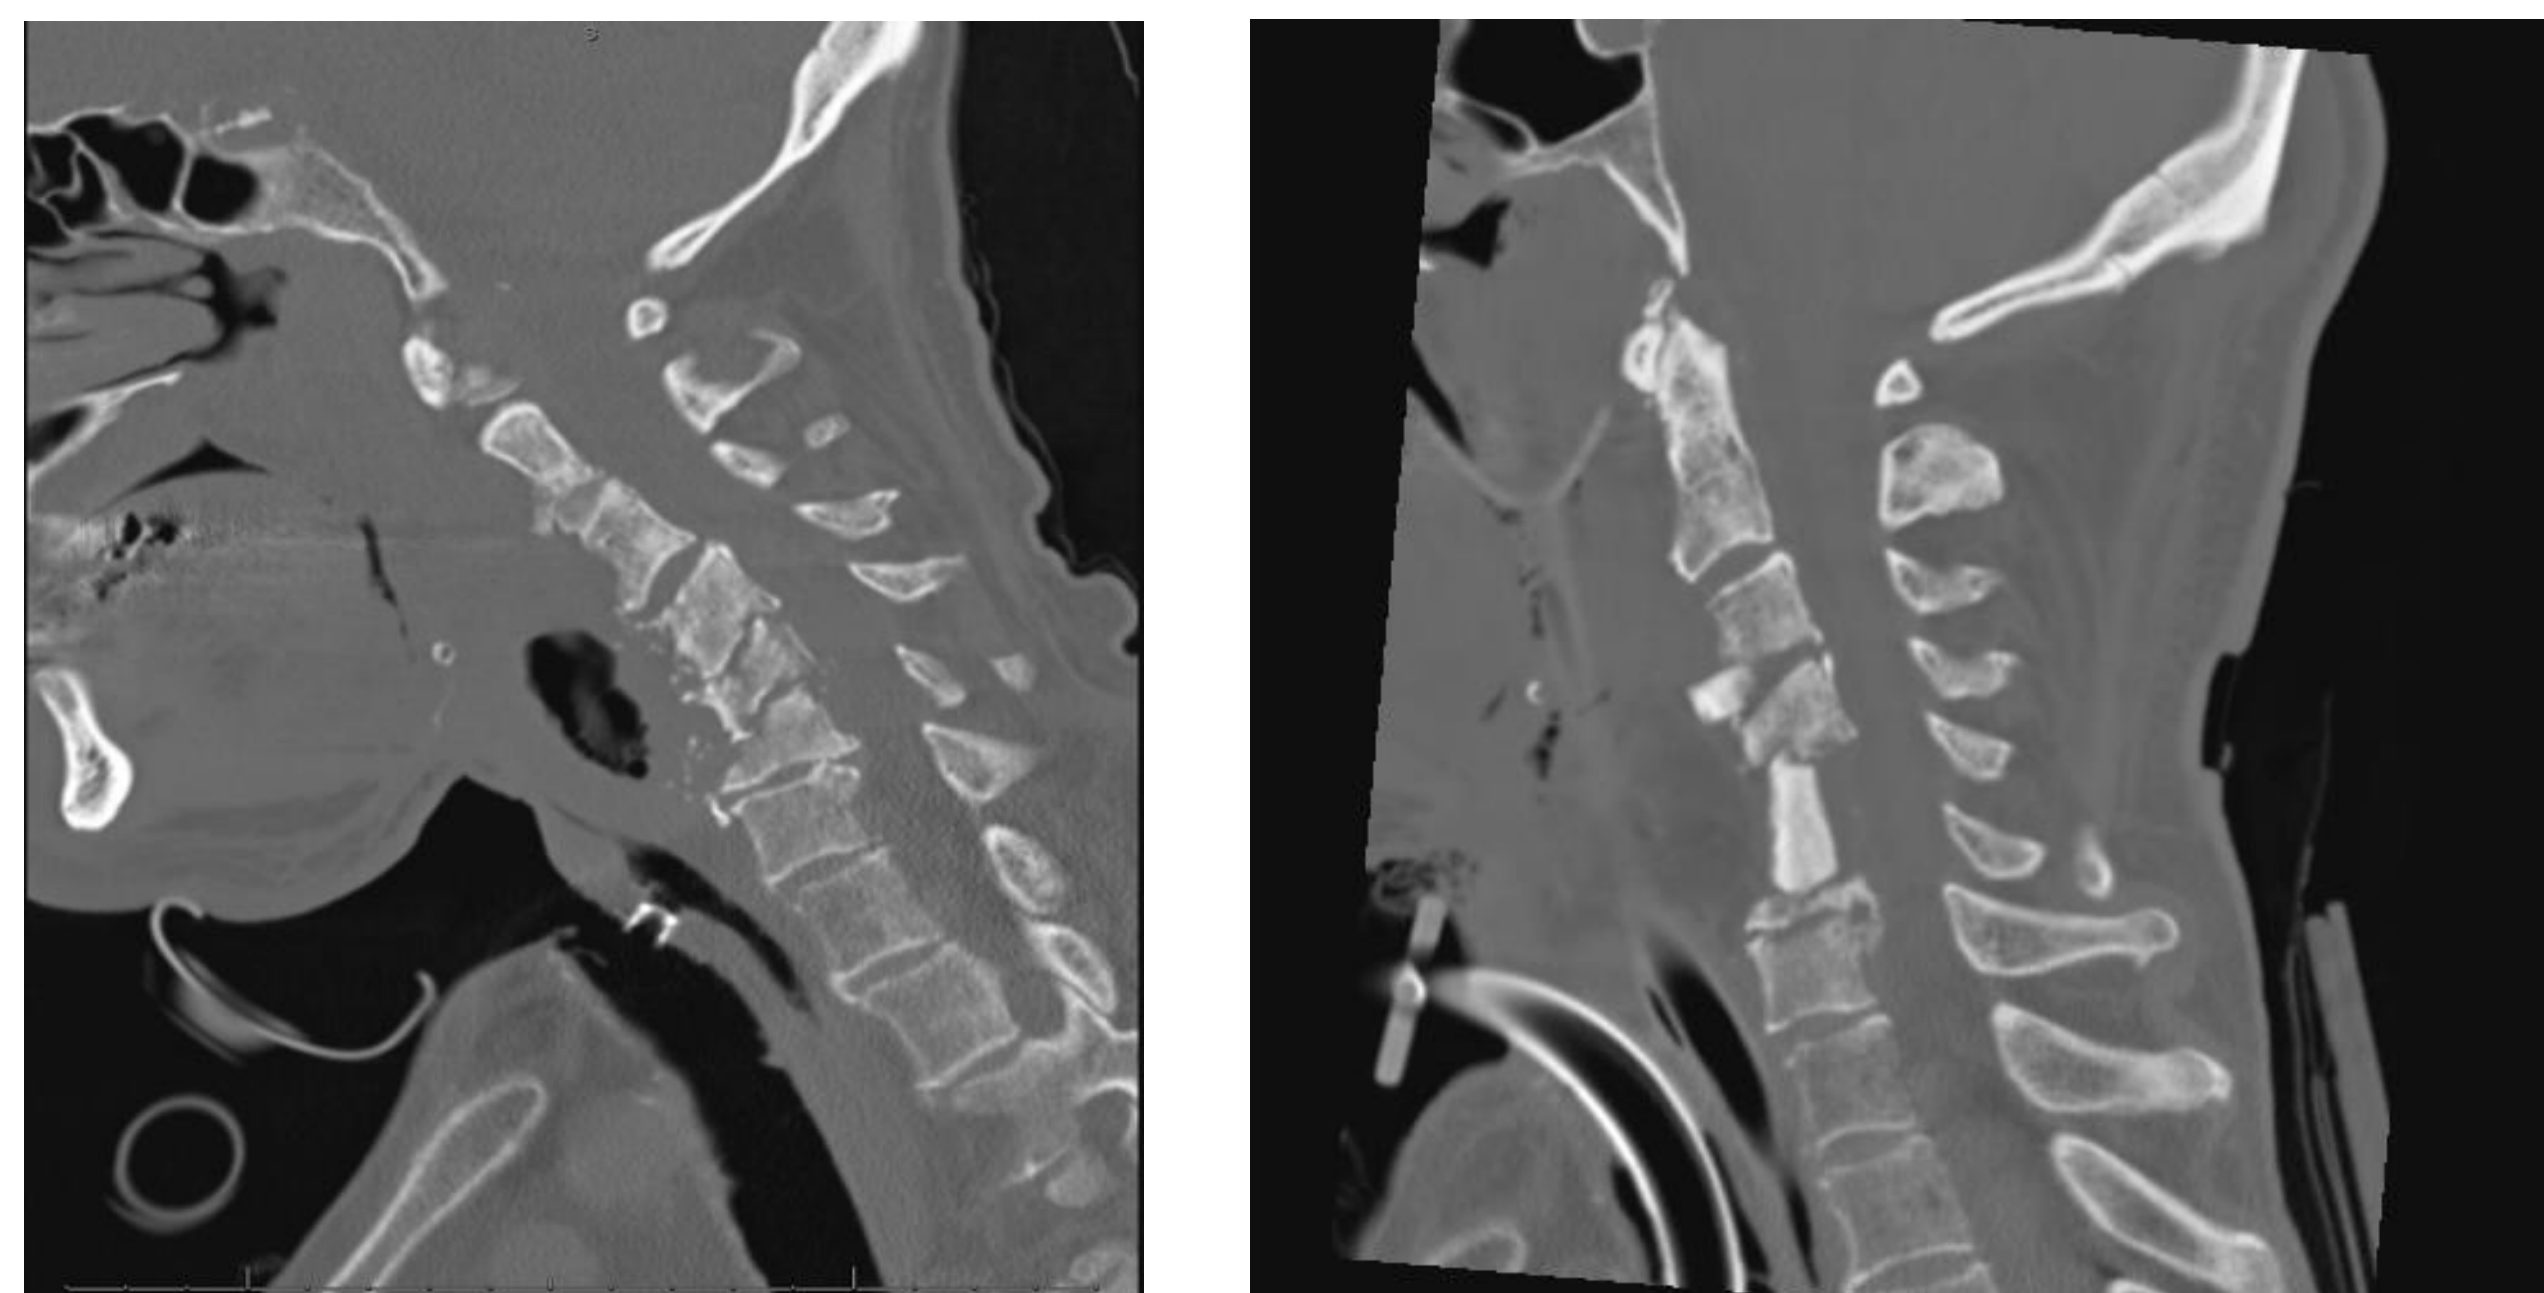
A Preoperative CTC-spine Sagittal View, demonstrating destructive bony lesions. B Postoperative CT C-spine Sagittal View showing iliac crest autograft reconstruction.
